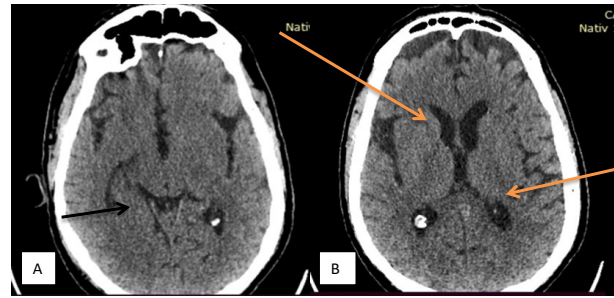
A. Postoperative axial CT scan. Normalization of the quadrigeminal cistern (disappearance of the culmen hernia) - black arrow. B. Normalization in ventricular dimensions - Orange arrow.
